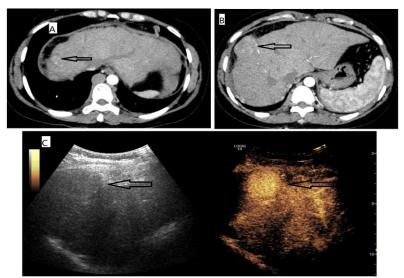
Case 2: The patient was with HCC. In the patient, CEUS detected only 1 lesion, while CECT detected 2 lesions. Contrast-enhanced computed tomography; CEUS: Contrast-enhanced ultrasound
